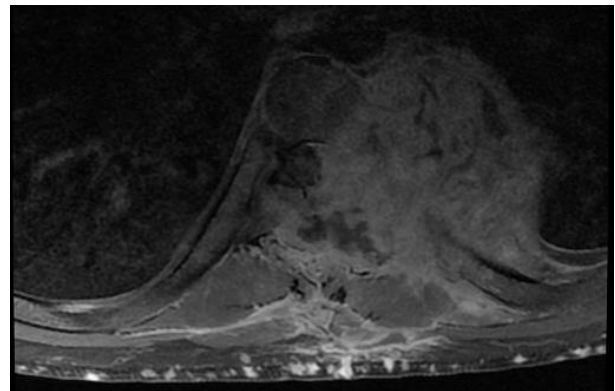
Postoperative spinal MRI showed a slight increase of the tumor formation with respect to D₁₁-D₁₂, in isotense T1, T2, heterogeneously enhanced after contrast with central necrosis, with a foraminal starting point measuring 88 x 95x88 mm, with external canal extension.
